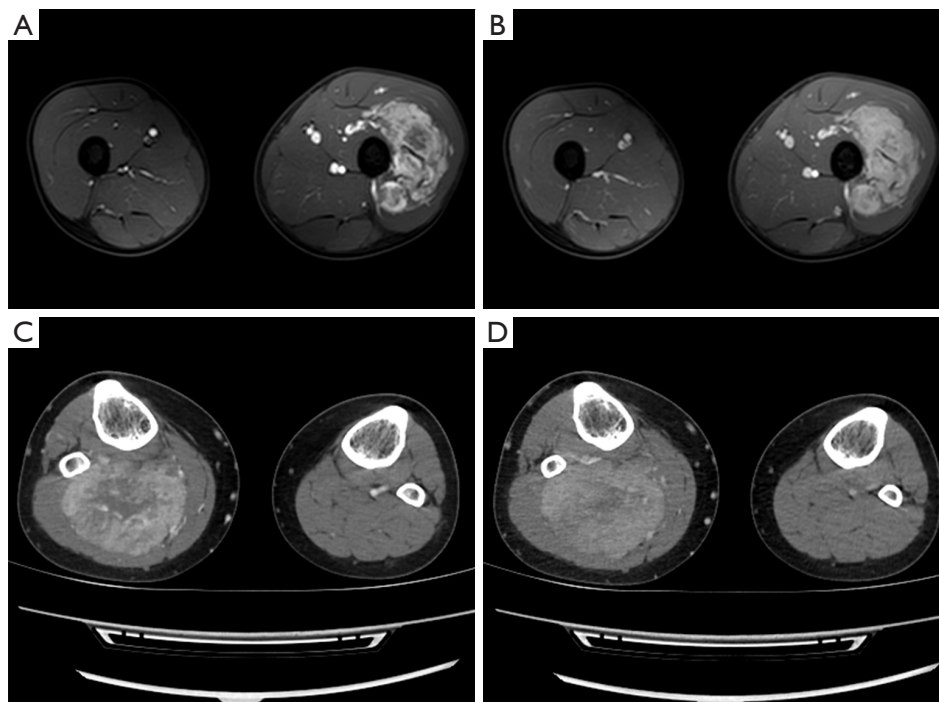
The DCE-MRI and CT findings of ASPS. The mass manifested early arterial enhancement at 2'30'' (A) and intense persistent enhancement at 4'22'' (B) on the DCE-MRI on 3.0-T MRI scanner, and the mass manifested intense persistent enhancement on the CT image (C,D). DCE-MRI, dynamic contrast enhanced-magnetic resonance imaging; CT, computed tomography; ASPS, alveolar soft part sarcoma.
